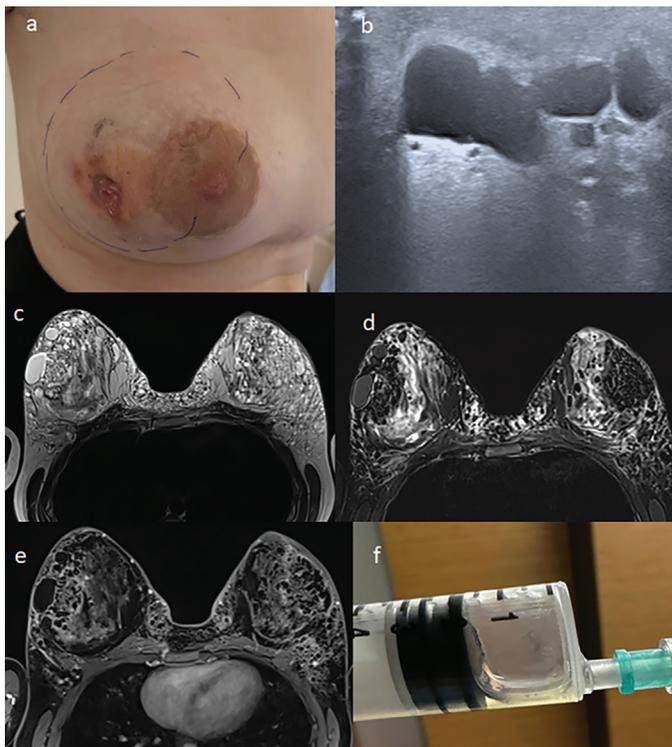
(a) Clinical appearance showing multiple skin ulcers and palpable masses in both breasts. (b) Ultrasound image demonstrating diffuse skin thickening, edematous subcutaneous tissue, and multiple well-defined anechoic cystic lesions with hyperechoic halos. (c-d) Magnetic resonance imaging showing cystic lesions with fat signal characteristics (hyperintense on T1- and T2-weighted images with signal loss on fat-suppressed sequences). (d) The glandular tissue shows marked T2 hyperintensity consistent with edema. (e) On contrast-enhanced fat-suppressed T1-weighted images, a thin rim-like enhancement is observed around these cystic structures. (f) Oily-appearing aspirated material obtained during ultrasound-guided aspiration
